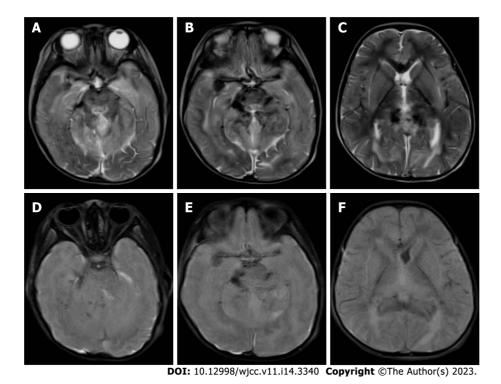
The imaging findings of head magnetic resonance on day 26 after admission. A-C: T2-weighted imaging showed blurred boundary between gray matter and white matter, structural disorder of brain stem and cerebellar hemisphere, and multiple long T2 signal shadows; D-F: Fluid-attenuated inversion-recovery (FLAIR) images showed blurred gray and white matter, disordered structure, high FLAIR signal around the cerebellum and lateral ventricle, and significant narrowing of the lateral ventricle.
